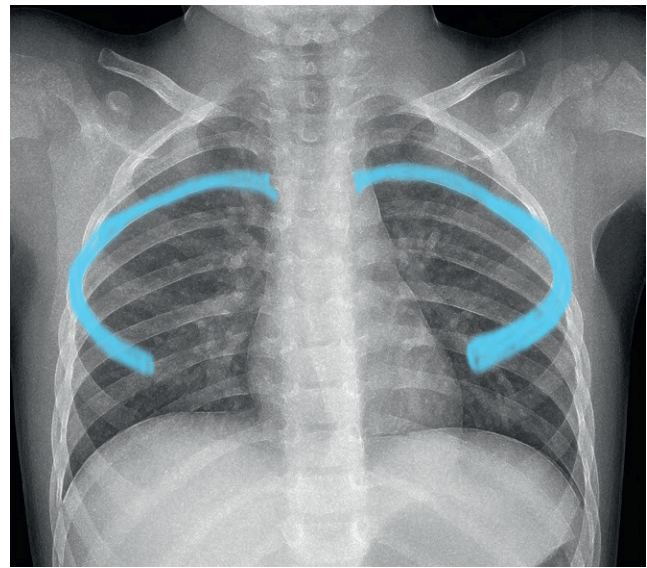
Radiograph of the thorax with the 4th ribs highlighted
